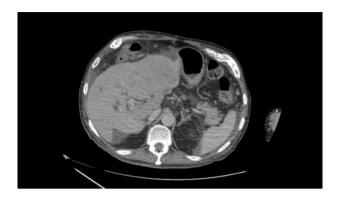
Simple phase CT scan showing a hypodense, oval-shaped lesion occupying the left and part of the right hepatic lobe, measuring 135×94×110 mm, with portal displacement.
